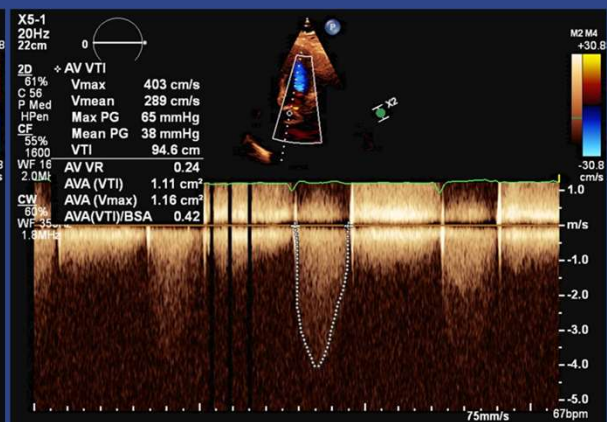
Apical CW Doppler across surgical AV "buddy sonographer" assisting, from author's clinical collection, di-identified (M.Trump, 2025)
